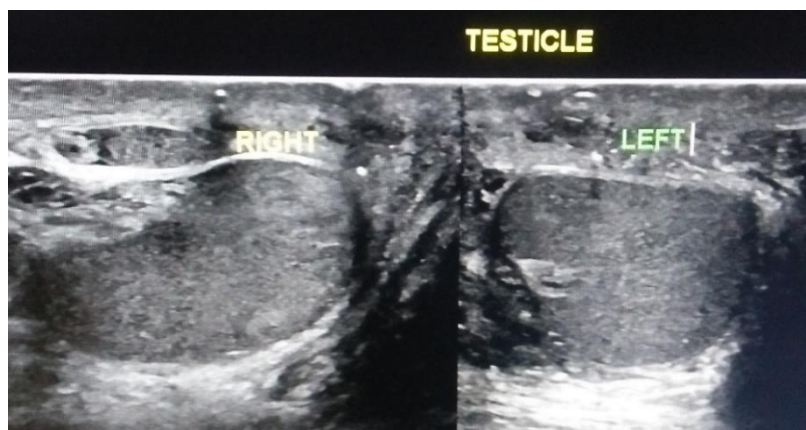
Postoperative scrotal ultrasonography showing normal echogenicity of both testicle
